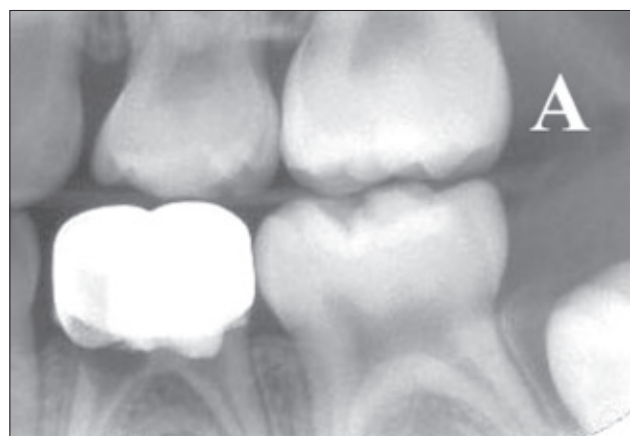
Left bite-wing radiograph of a 5-year, 2-month-old girl. Primary mandibular first molar with internal resorption in the mesial root 7 months after performance of pulpotomy with formocresol.
